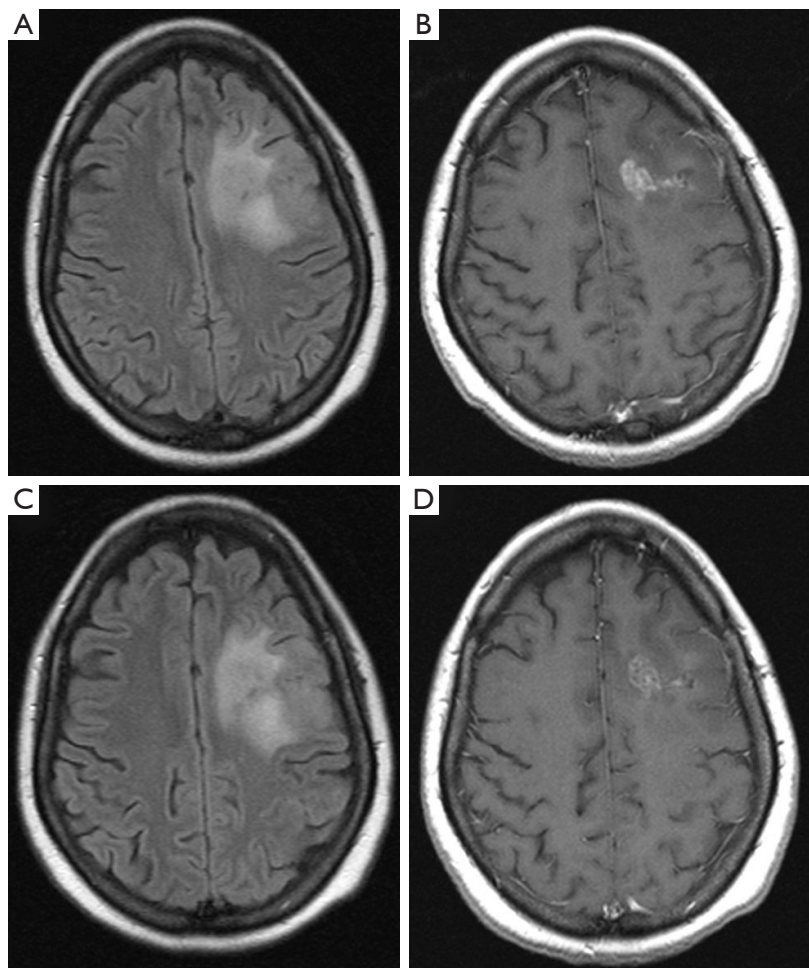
Oligodendroglioma grade 2 of the left frontal lobe surgically treated and subsequently underwent radiation therapy. (A,C) Axial FLAIR images; (B,D) axial T1 contrast-enhanced images. (A,B) MRI performed after 7 months from the surgery and after 3 months from the radiation therapy with a residual area of contrast enhancement and FLAIR hyperintensity. (C,D) Follow up MRI performed after 3 months from (A) and (B) showing a mild decrease in the FLAIR hyperintensity and contrast-enhancement. One rater assigned a BT-RADS category 2 as for stable disease. However, given the improvement in FLAIR and enhanced images, BT-RADS 1a is more appropriate. FLAIR, fluid attenuated inversion recovery; MRI, magnetic resonance imaging; BT-RADS, Brain Tumor Reporting and Data System.
